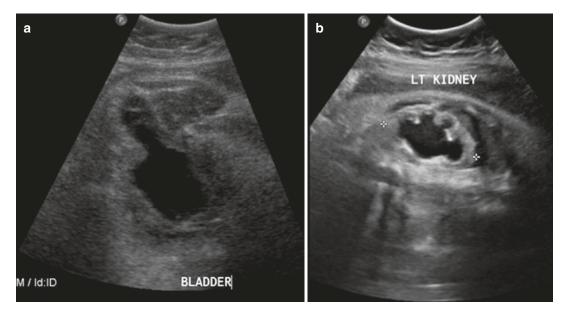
Sonographic features suggestive of PUV detected during antenatal evaluation: (a) thick-walled bladder with prominent posterior urethra, the "key-hole" sign; (b) high-grade hydronephrosis
